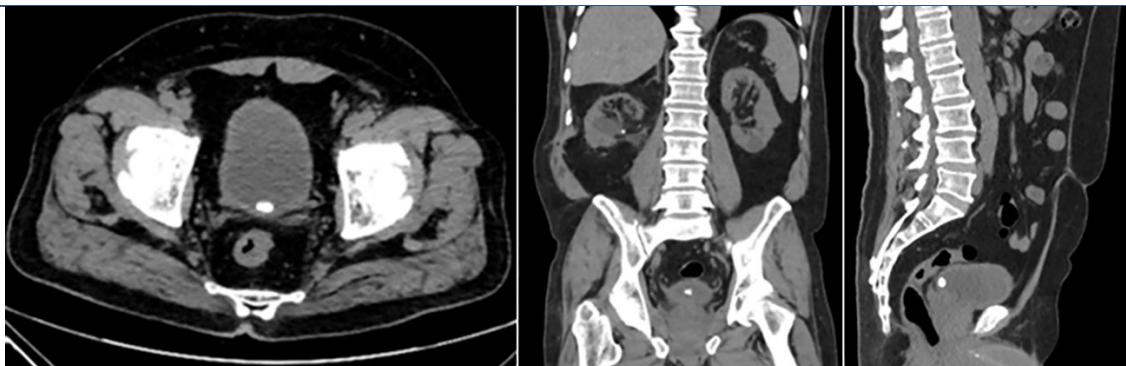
A review of a prior standalone abdominopelvic computed tomography (CT) scan, performed approximately one week earlier, revealed the existence of a stone within the bladder, while showing no evidence of calcification or the presence of a stone in the prostate gland area. These observations suggest that the urinary stone may have been displaced into the prostatic urethra
